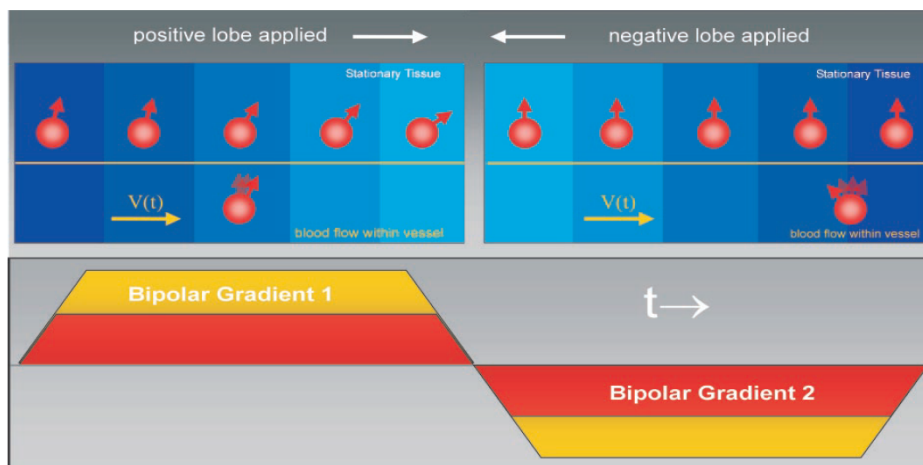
Principle of PC-MRI. Sequence of two inverted bipolar gradient is applied. Flow encoding is achieved by means of the difference in the bipolar gradients of the two acquisitions [61].
